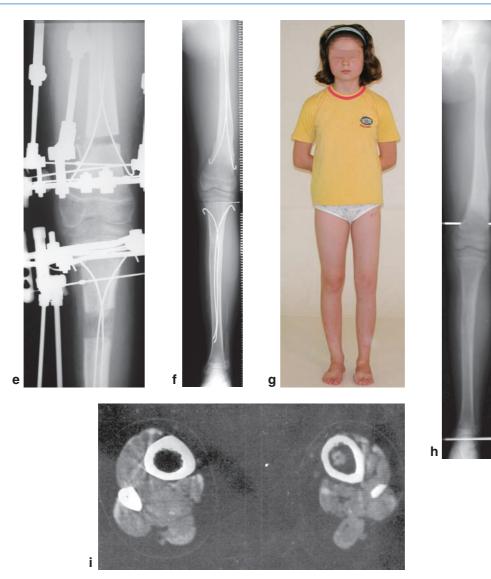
(*cont.*) (e) X-ray taken at initiation of femoral lengthening (i) on the fifth day of the fixation period for tibia; (f) AP view of the lower limb 2 months after removal of the external fixator; (g) 4 months after removal of the femoral external fixator and 15 days after removal of intramedullary
